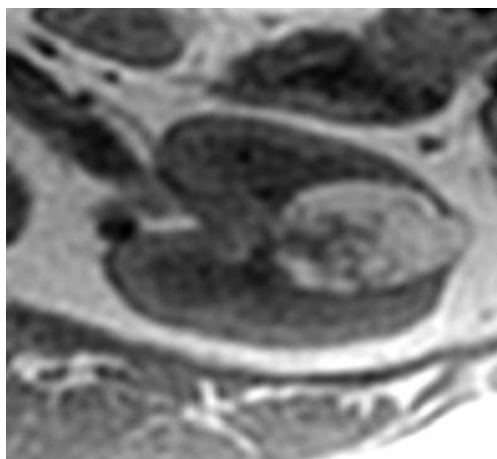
MRI showed a T1 hyperintense fatty lesion with moderate reticular enhancement of the non-fatty components.
